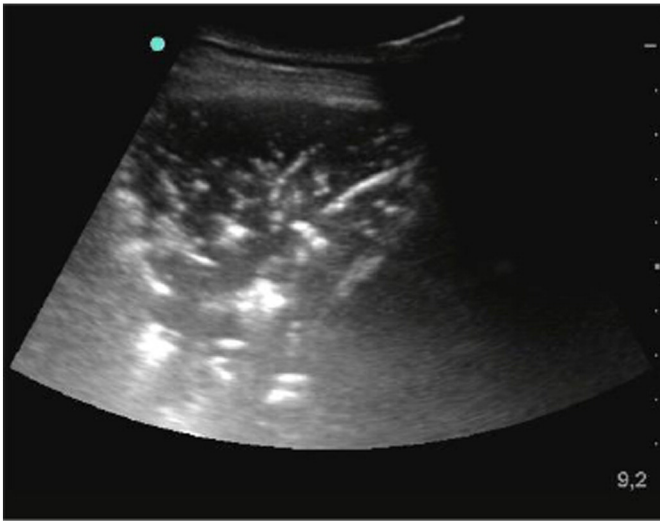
Typical lung ultrasound of alveolar syndrome.
